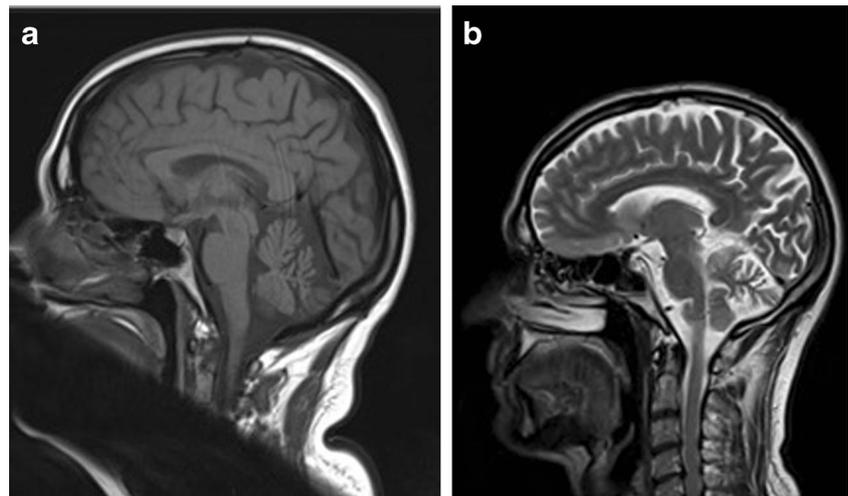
MRI brain imaging sagittal cut. a FLAIR brain imaging of the proband (II-7) showing cerebellar atrophy, b T2 brain imaging of the proband's brother (II-3) showing vermian atrophy
